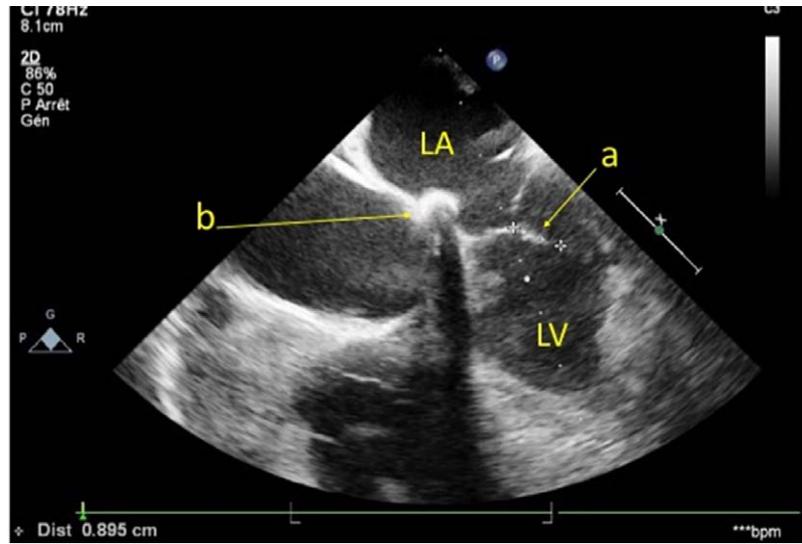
Echocardiogram with epicardial view of the four cavities. a, height of mitral leaflets coaptation; b, ring at the level of A2. LA, left atrium; LV, left ventricle.
